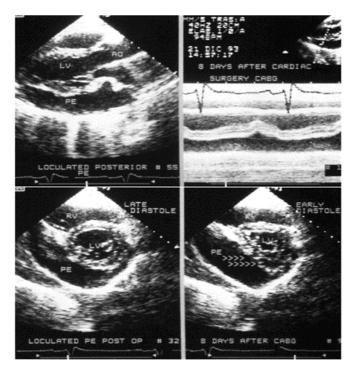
Parasternal long axis (top left), M-mode tracing (top right), and parasternal short axis in late diastole (bottom left) and in early systole (bottom right) in a patient with diastolic collapse of the left ventricle
